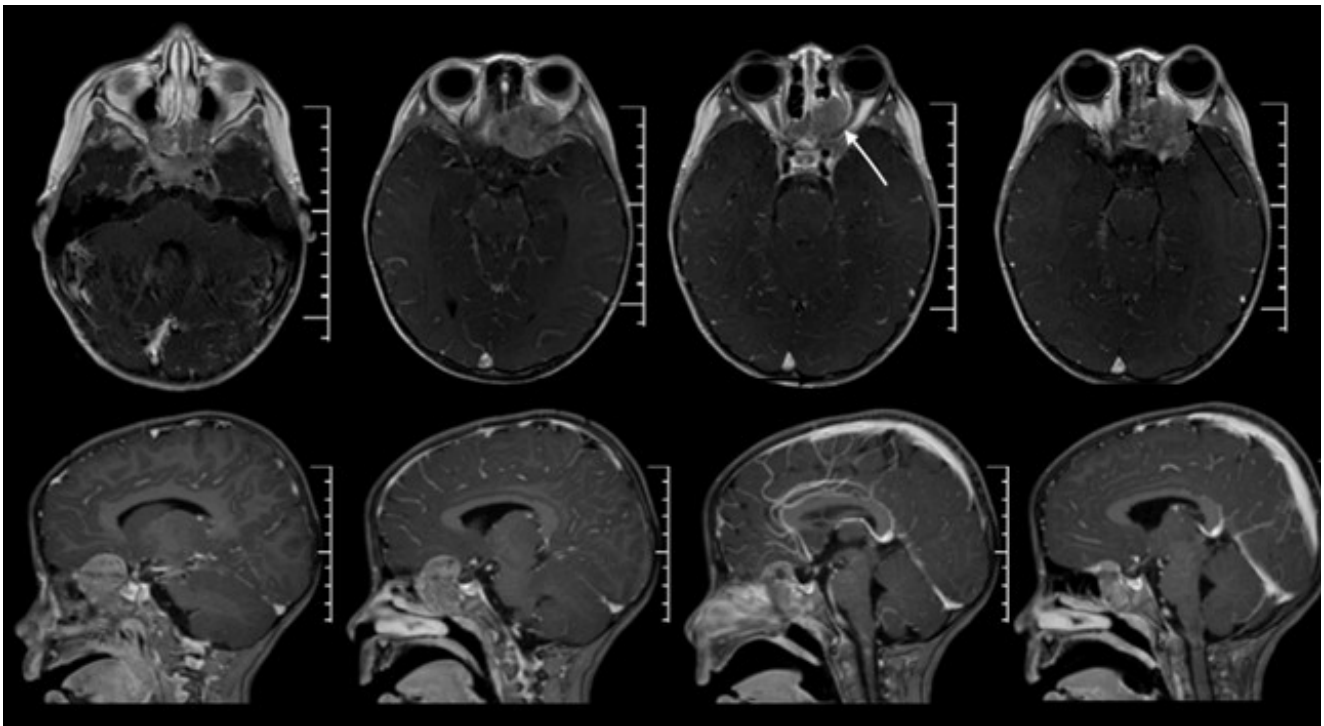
Axial and sagittal T1WI post gadolinium MRI demonstrating an enhancing tumor mass extending from upper clivus to anterior cranial fossa centered at the cribriform plate, ethmoid and sphenoid bone extending into right and left orbital cavity, compressing the optic nerve (white arrow) and invading the periorbit (black arrow). A proptosis is seen in the left eye.
